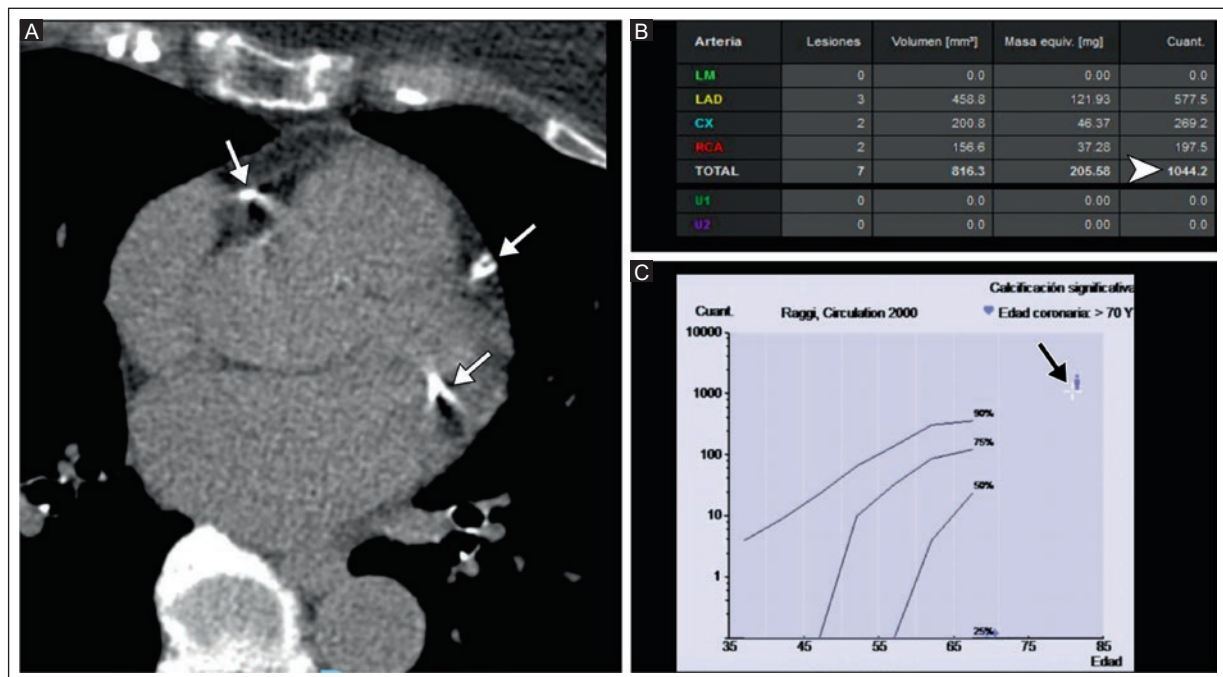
A 76-year-old asymptomatic woman with type 2 diabetes, dyslipidemia, and smoking. A: axial view of coronary CT calcium score with CAC (arrows). B: table of CAC volume and mass values determined by AS (arrowhead). C: the percentile chart shows AS with significant CAC by ethnicity and age, with percentiles above 90% (black arrow) based on MESA.
